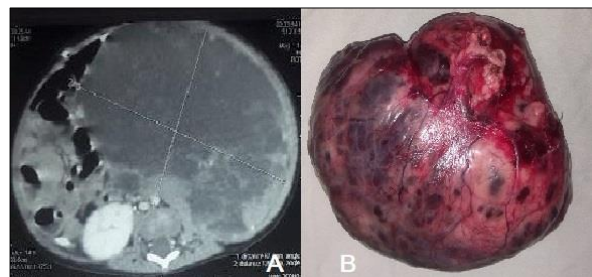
A) CT scan showing recurrent CMN tumor. B) Excised recurrent CMN tumor.
